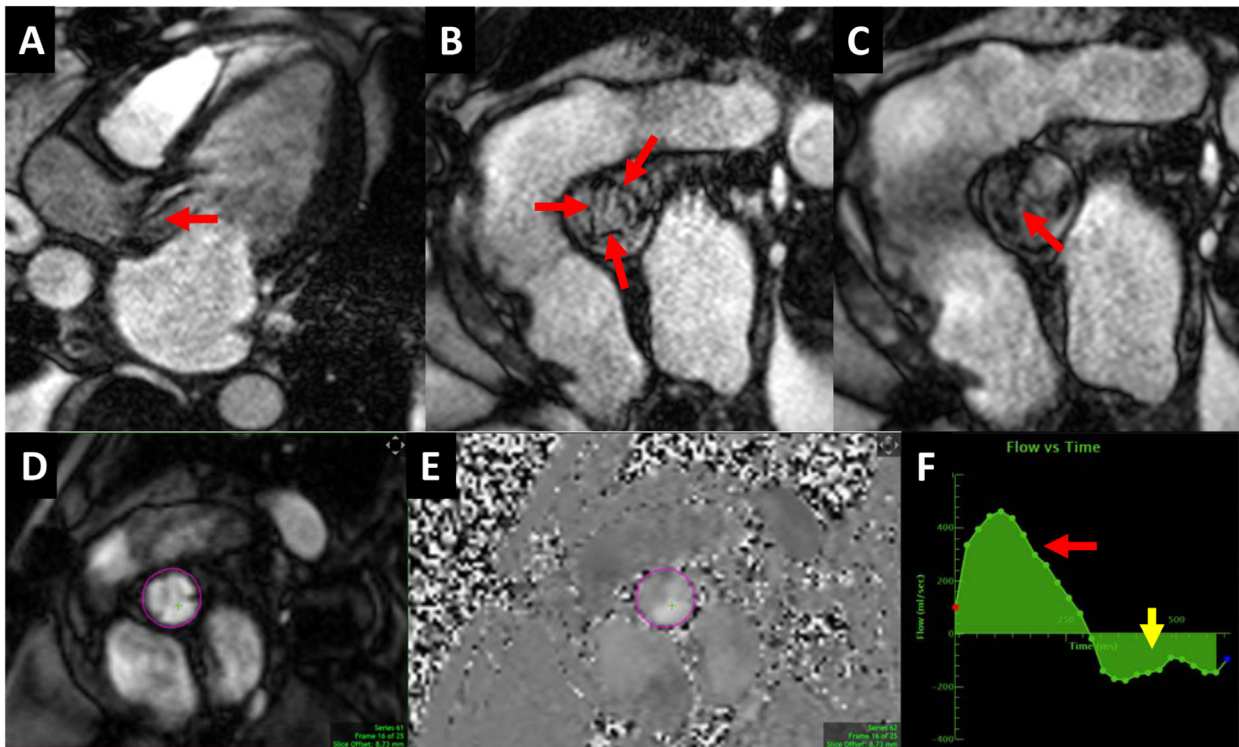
Cardiac magnetic resonance imaging of a case with severe bioprosthetic AR. (A) Three-chamber long-axis view on steady-state free precession cine CMR showing spin dephasing in diastole across the valve, suggestive of turbulence from AR (red arrow). (B, C) Short-axis views of the bioprosthetic valve in systole showing normal systolic excursion (B, three arrows) and leaflet malcoaptation in diastole (C, arrow). (D-F) Magnitude and phase-contrast CMR sequence with region of interest at the level of sinotubular junction. Flow-vs-time curve (F) shows forward (red arrow) and backward (yellow arrow) flow for direct assessment of AR (regurgitant volume = 55 mL).
